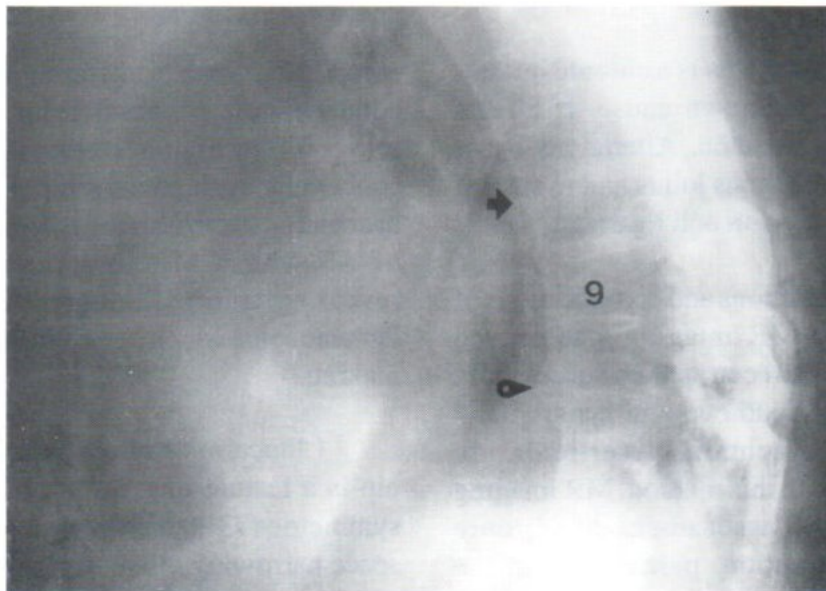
Lateral thoracic spine radiograph reveals nearly complete obliteration of T7-8 disk space (arrow), with diskovertebral destruction at the level of T10-11 (round arrowheads). (Number 9 indicates level of T9)
